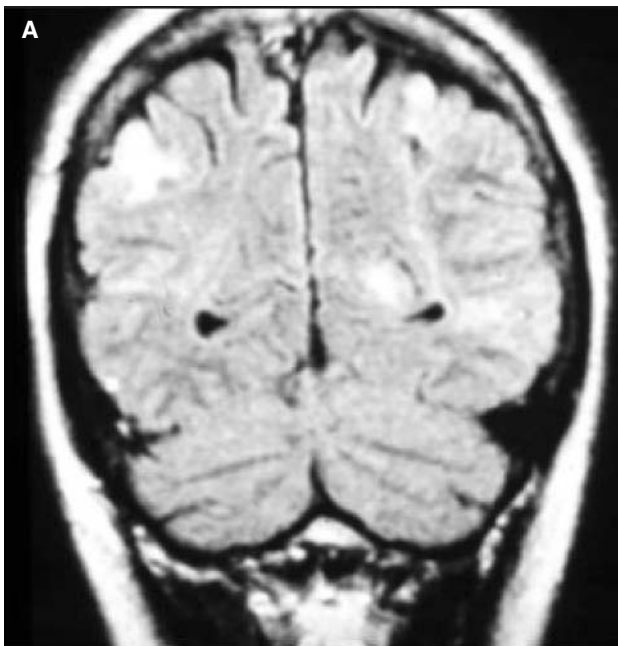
Coronal (A) and axial (B) T1-weighted magnetic resonance images of the brain showing (A) rounded high signal lesions in the cortical (tubers) and radial (TSC white matter abnormalities) high signal lesions in the subcortical white matter and a cystic lesion (B) within a subependymal nodule which is transforming in a giant cell tumour.
